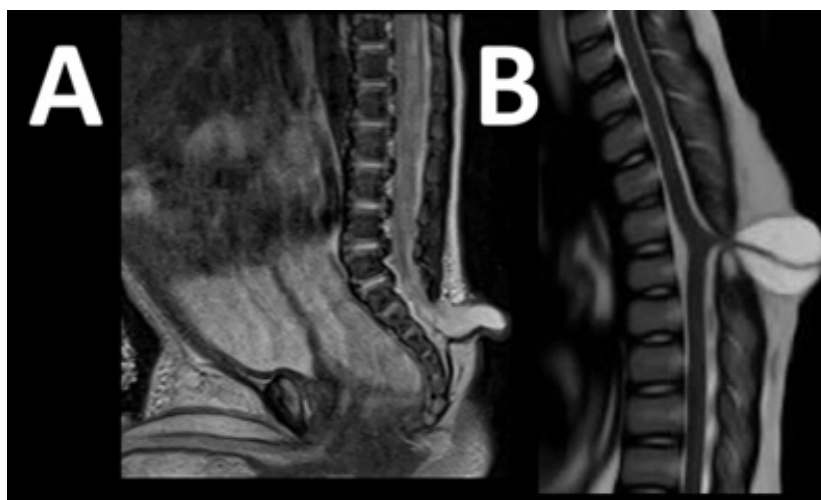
MRI sections show myelocele (A) and myeloschisis (B).
